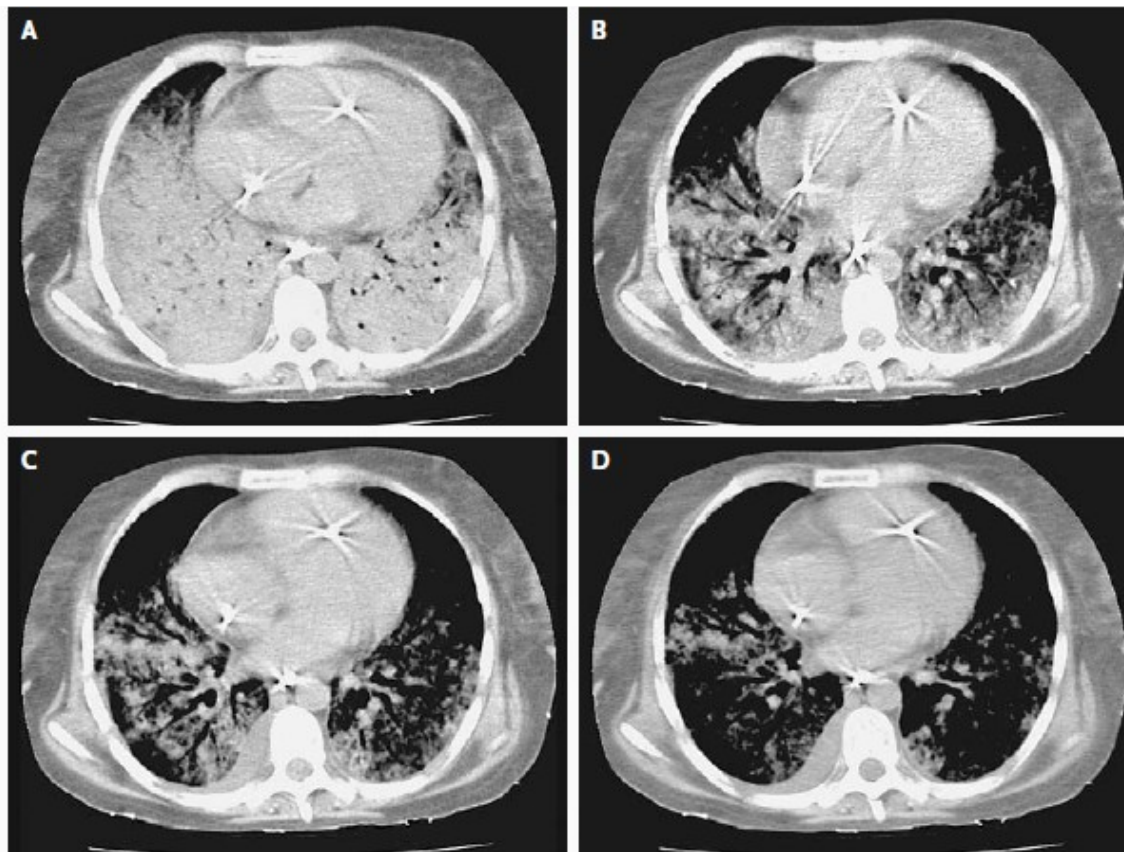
Computed Tomographic Images Obtained at the End-Expiratory Pause in a Patient with Pneumocystosis and the Acute Respiratory Distress Syndrome.
